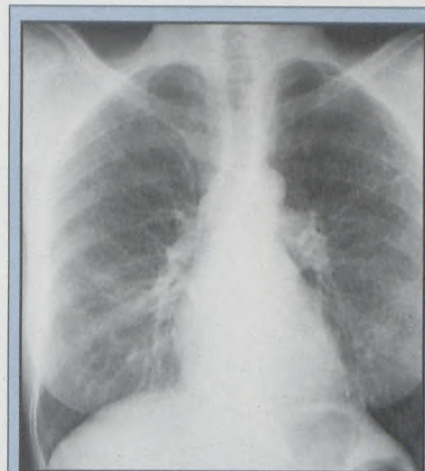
Chest radiograph of a 59-year old woman with hut lung showing the diffuse fine nodular interstitial pattern with loss of vascular clarity.
